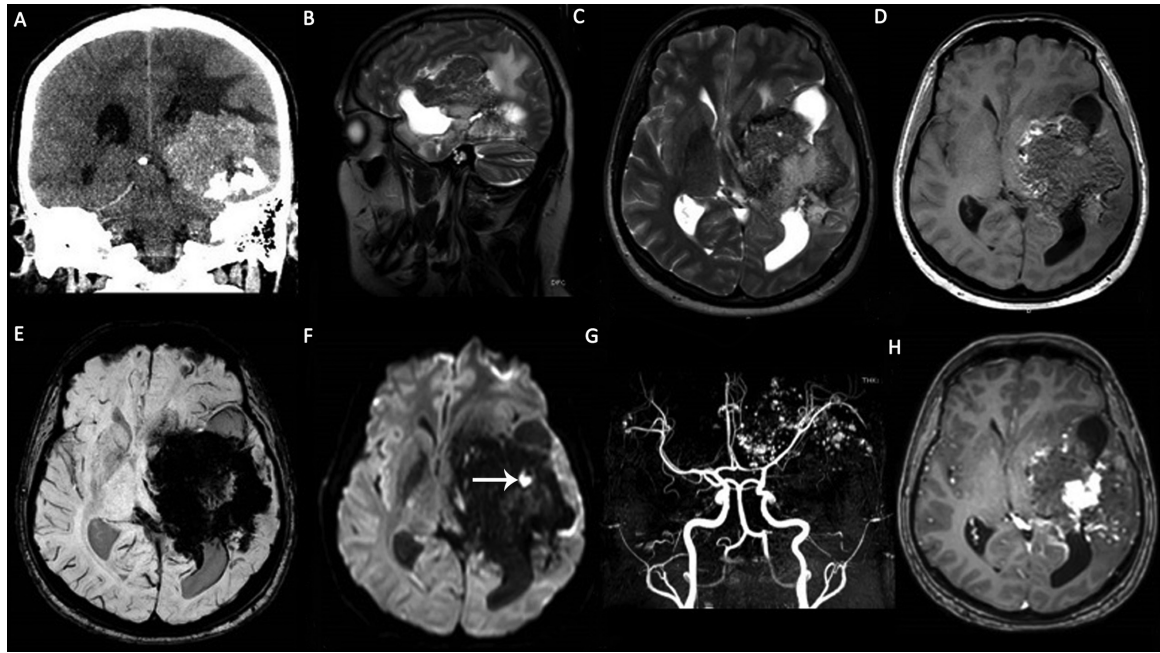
A left cerebral hemisphere giant cavernous malformation (CM) in a 33-year-old male patient with seizure and headache. (A) Coronal computed tomography (CT) scan demonstrates a large heterogeneous calcified mass in the left cerebral hemisphere. (B) Sagittal T2-weighted image (T2WI), (C) axial T2WI and (D) axial T1WI show that the mass demonstrates heterogeneous signals with “salt and pepper” appearance on nonenhanced T1WI. (E) Susceptibility-weighted imaging (SWI) demonstrates intense “blooming artifacts” due to calcifications and chronic hemorrhage. (F) The mass is mainly hypointense on diffusion-weighted imaging (DWI) and includes a focal-restricted diffusion due to a recent hemorrhage (arrow). (G) Axial view of the maximum intensity projection (MIP) of the time-of-flight magnetic resonance (MR) angiography shows the cavernoma vessels in the left cerebral hemisphere. (H) Contrast-enhanced T1WI demonstrates heterogeneous enhancement.
